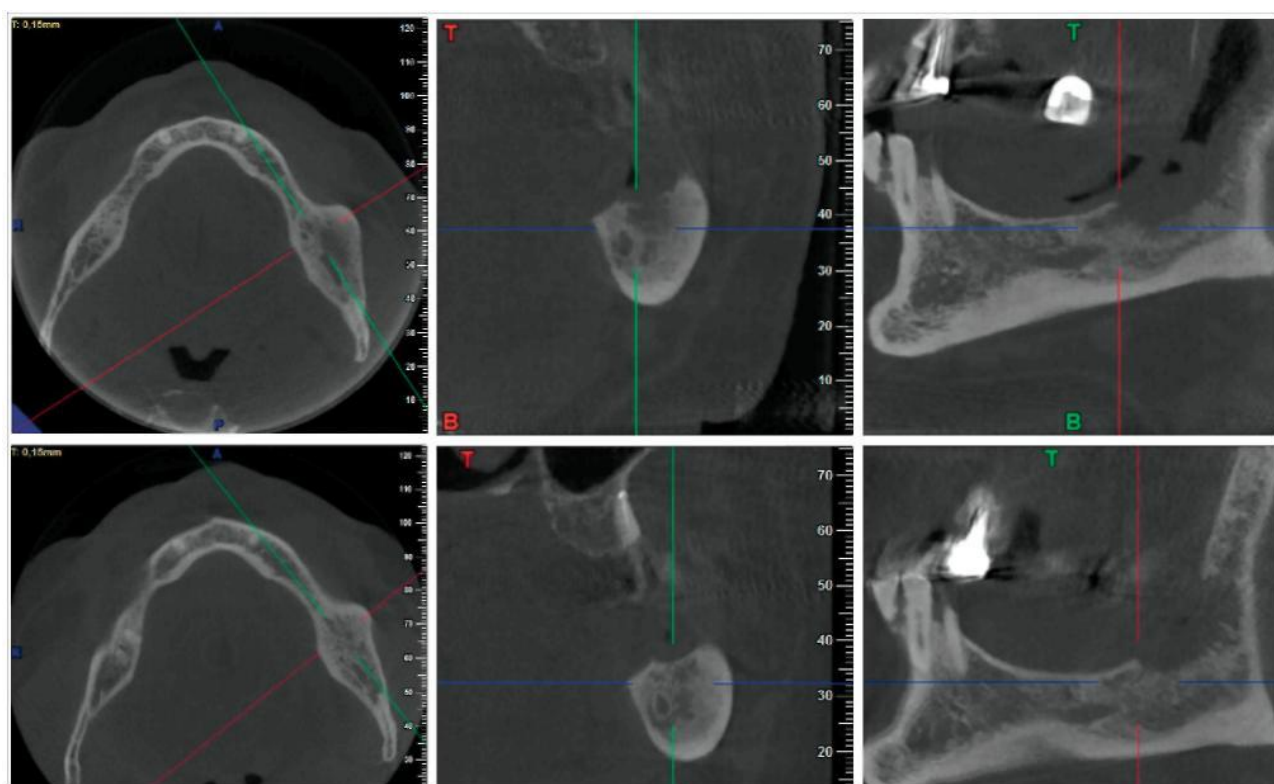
Comparison of CT profiles taken 9 months (upper series) and 17 months after decompression (bottom series)
